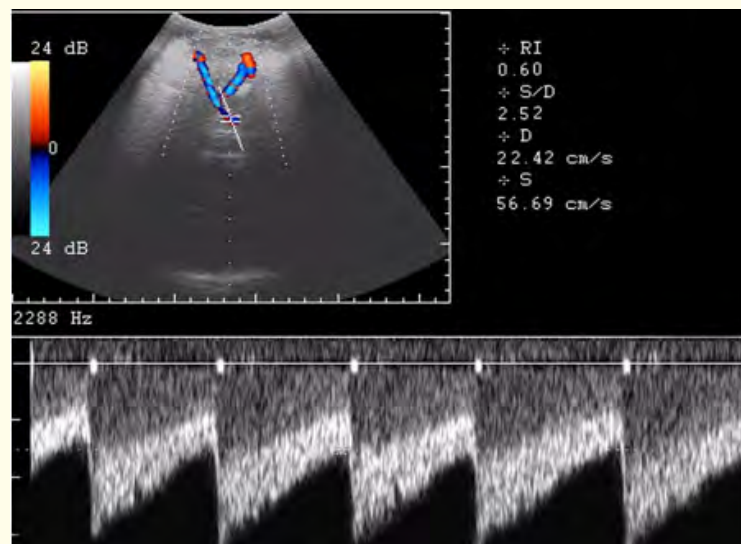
Doppler spectrum of the blood flow in basal artery in neutral position of patient. Vs is 56,69 cm/c, RI - 0,60.
